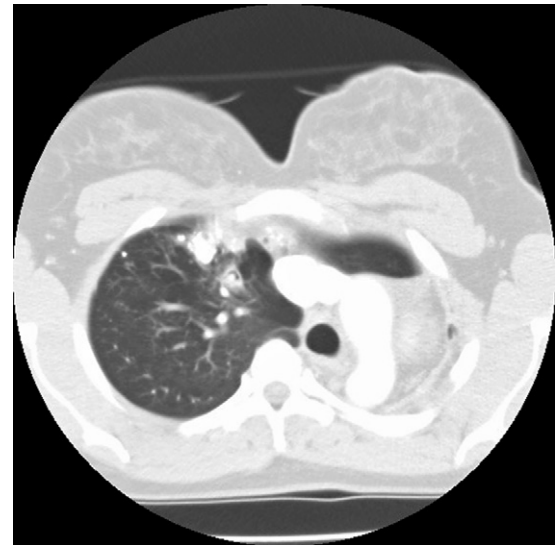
CT thorax showing right upper lobe fibrosis and calcification along with aspergilloma. Air crescent sign or Monod's sign.
